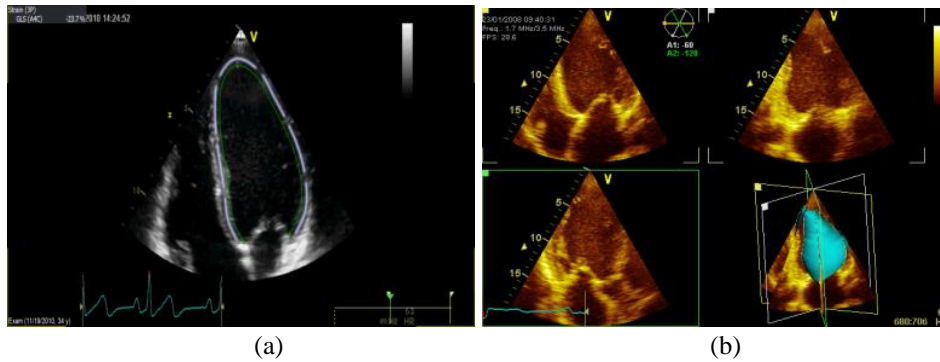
(a) Global longitudinal strain (GLS) Speckle tracking echocardiography (left) which can detect any early subtle systolic dysfunction among obese diabetic patients. (b) Three-dimensional echocardiography (right) of patient with T2DM-induced dilated cardiomyopathy. These images are typical on several similar cases. GEN Elkilany.
